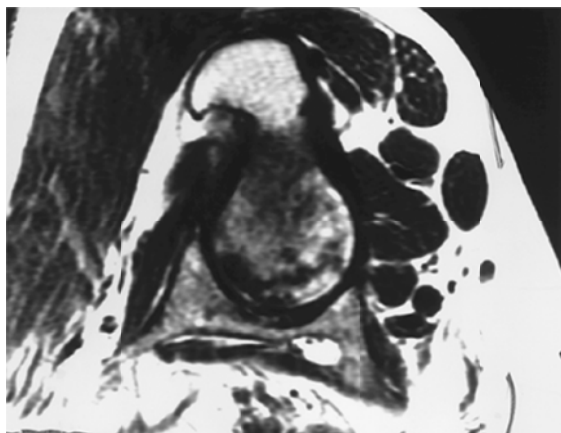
Avascular necrosis: T1-weighted magnetic resonance imaging.
